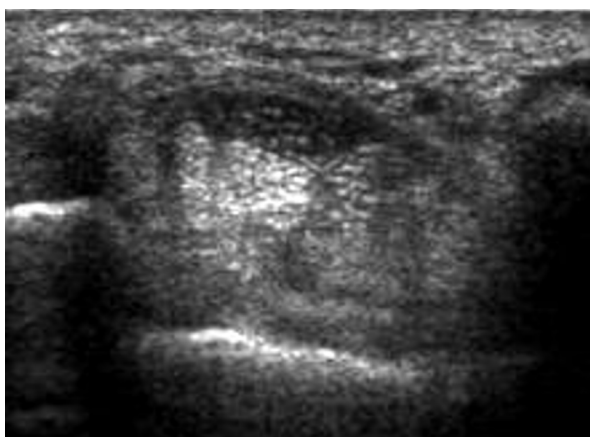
Carpal tunnel syndrome in a 42-year-old woman. Transverse 5-12 MHz sonographic scan shows oval cross-section shape of the massively enlarged (24 mm²) median nerve
